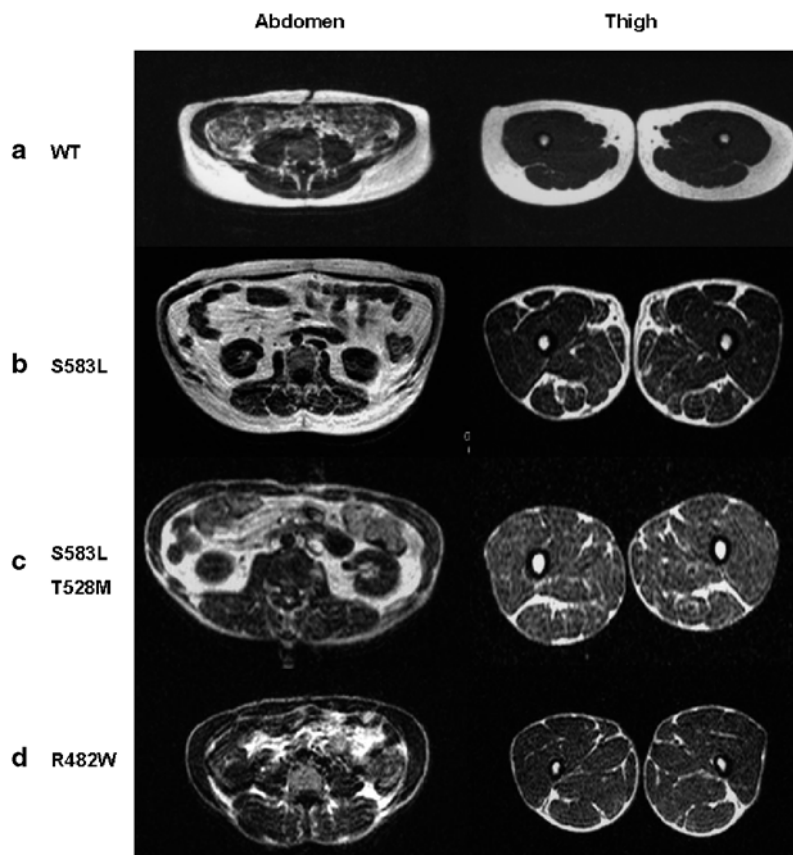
Characterisation of fat distribution. Transverse T1-weighted magnetic resonance images of the abdomen and thighs from women with *LMNA* mutations: (a) Lean, healthy control female (WT, wild type for *LMNA* gene); (b) S583L alone (subject AI); (c) S583L and T528M (subject CI); (d) R482W (30-year-old woman). Note that while subcutaneous abdominal fat is strikingly reduced in typical Dunnigan-type FPL (R482W) and the compound heterozygote, it is preserved in the subject harbouring the S583L mutation alone
